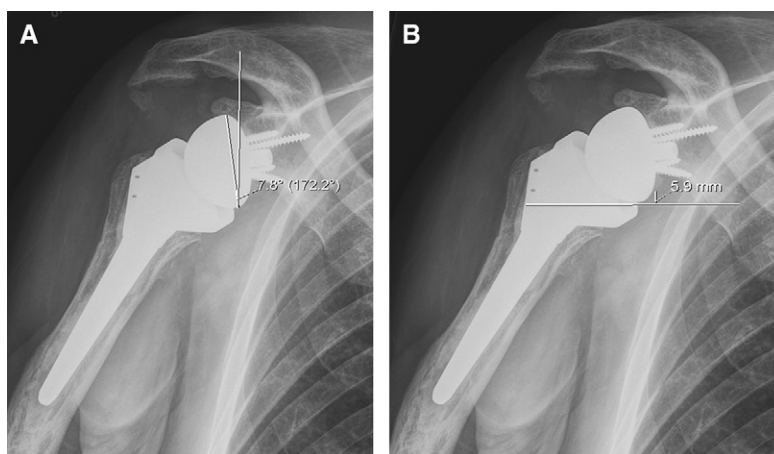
Radiographic examples of the measurement of (A) glenosphere height and (B) glenosphere inclination.
